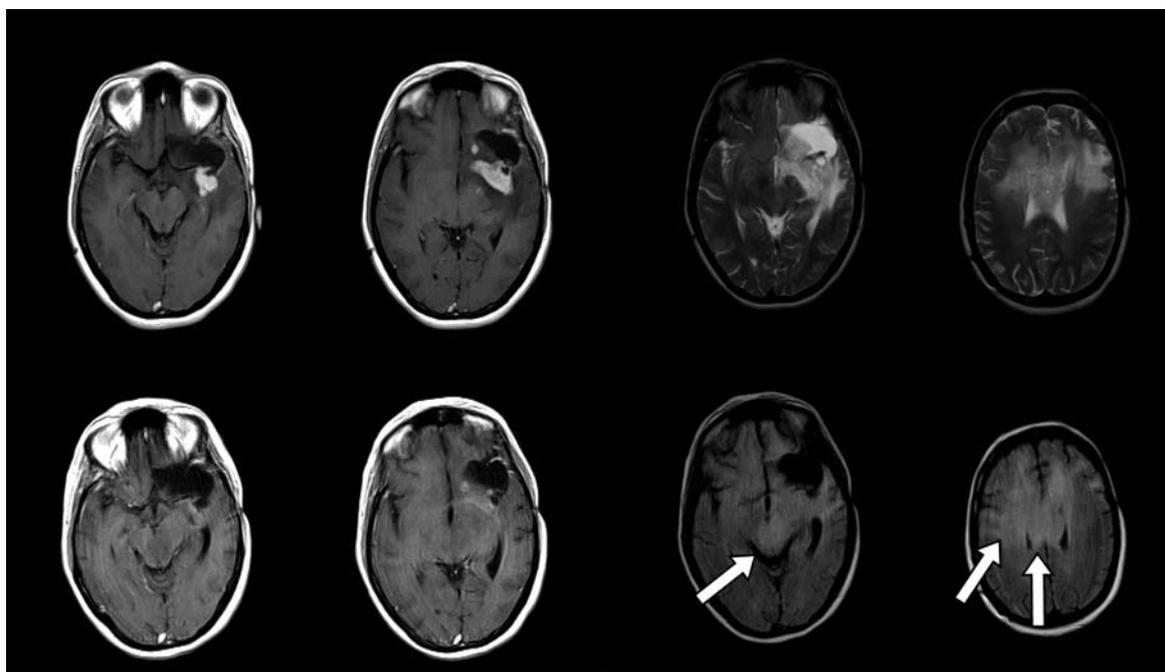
MRI of a patient with bevacizumab-induced 'pseudo response', before (above) and after (below) bevacizumab: T<sub>1</sub>-weighted gadolinium-enhanced (left two columns) and FLAIR (right two columns) images showing disease progressing (arrows) in the brain stem and temporal lobe.
